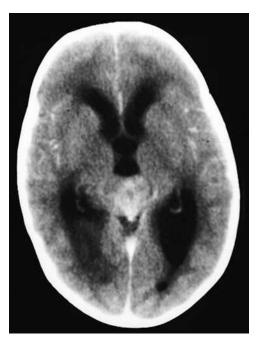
Pineal region tumor. CT scan of a patient with headache, lethargy, vomiting, and paresis of upward gaze shows an enhancing mass lesion in the pineal region and severe obstructive hydrocephalus. (Courtesy Department of Neuroradiology, University Health Center of Pittsburgh, Pittsburgh, Pa.)
